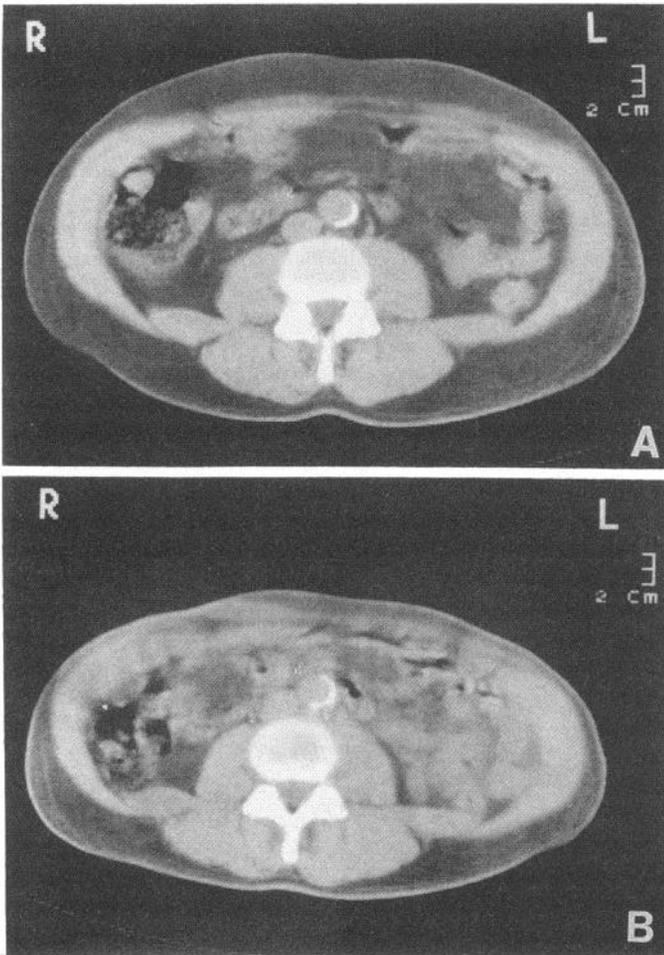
CT scan at the L3-L4 level (patient 2) before (A) and after 26 weeks of treatment with rhGH (B). The scan clearly demonstrates the reduction of both visceral and sc AT (shown in the pictures as dark grey).
